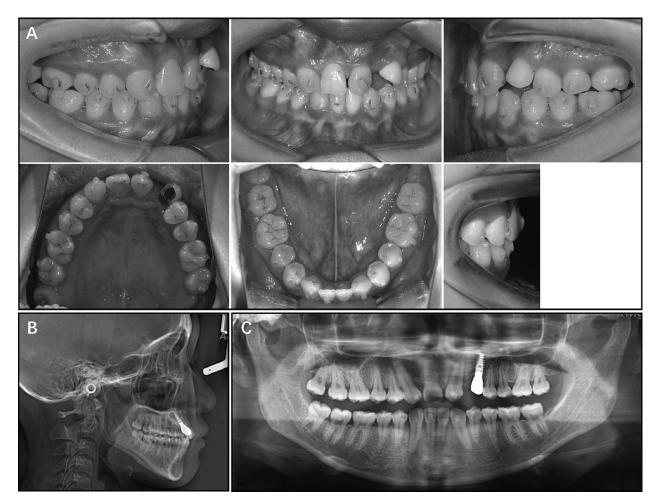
Records at the 16th month of the R0 treatment. (A) Intraoral photographs. (B) Lateral cephalogram. (C) Panoramic radiograph.
